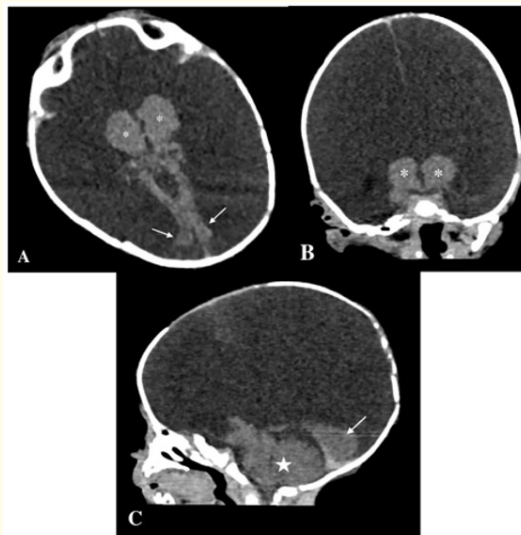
Axial (A), Coronal (B) and Sagittal (C) non-contrast computed tomography (CT) scans show no remaining cortical tissue, a preserved occipital lobes (arrow), thalami (asterisks), and posterior fossa (star). The falx is present.
